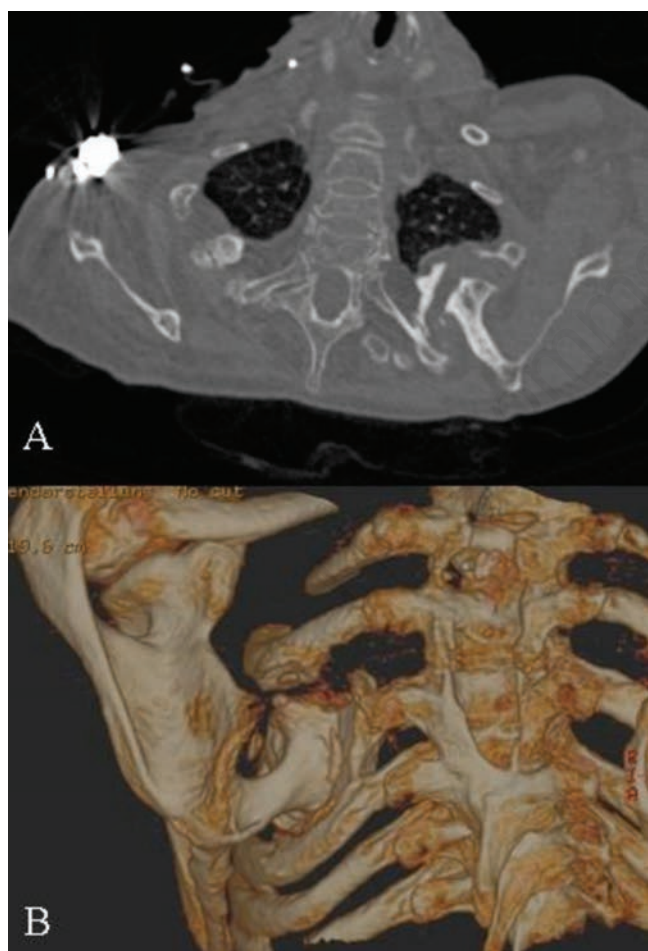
Axial (A) and 3D reconstructed (B) computed tomography scan. A and B show an osteochondroma rising from the left ventral scapula body forming a scapulothoracic neojoint.
